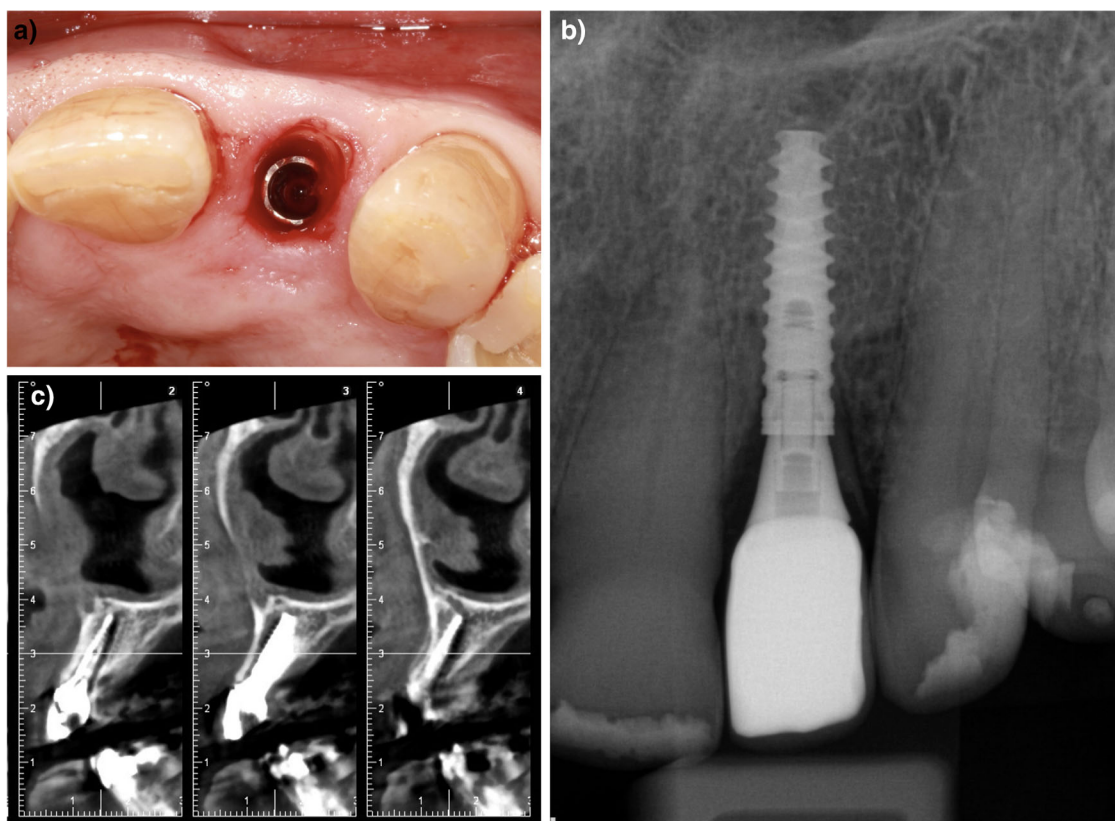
a Socket shield preparation and immediate implant placement. b A radiograph at 5 years after the prosthetic insertion. c A cone beam computed tomography (CBCT) image at 5 years after the prosthetic insertion.
